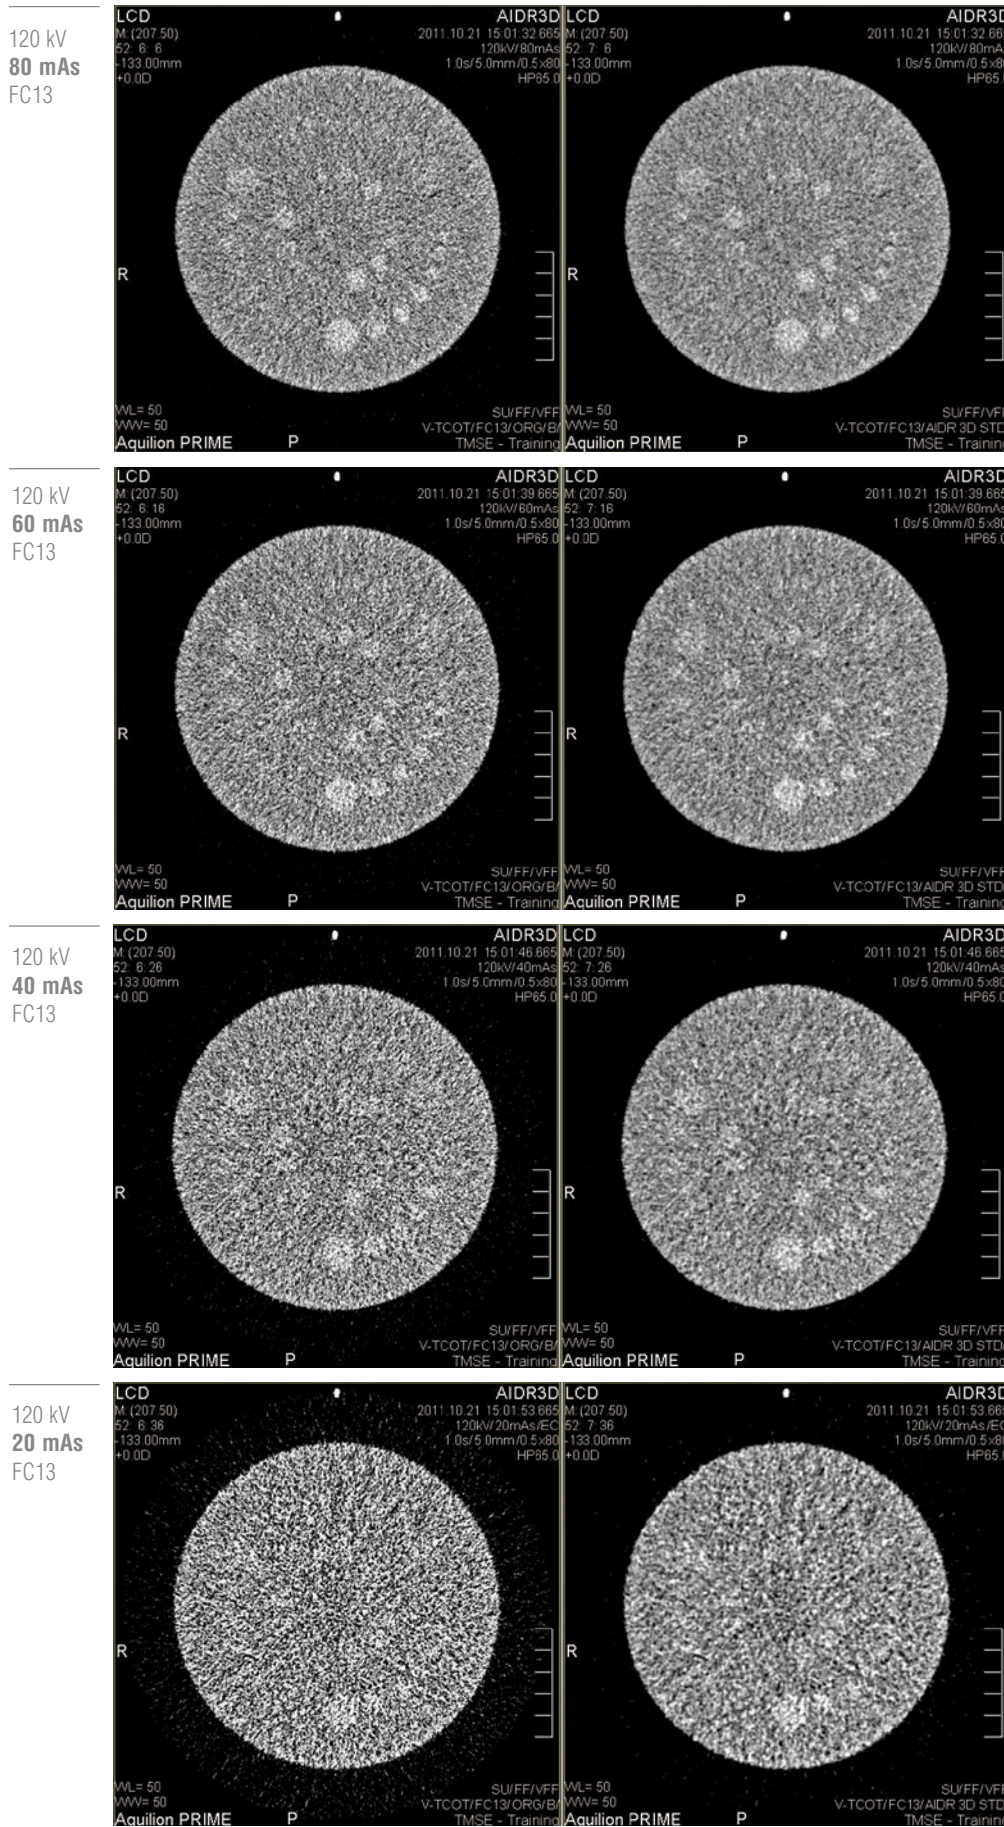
Low Contrast Detectability: axial images reconstructed using standard FBP (left), and AIDR 3D (right) from a clinical CT scanner. The mAs was reduced from top to bottom: 80, 60, 40, and 20 mAs, respectively, while keeping the kVp and FC filter constant.
